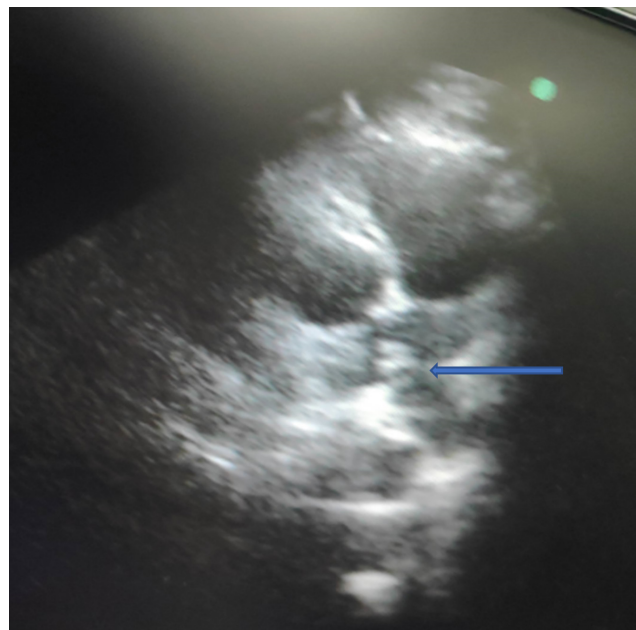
Parasternal short axis view in transthoracic echocardiography showing a large thrombus at the level of bifurcation of main pulmonary artery in right pulmonary artery (blue arrow).
